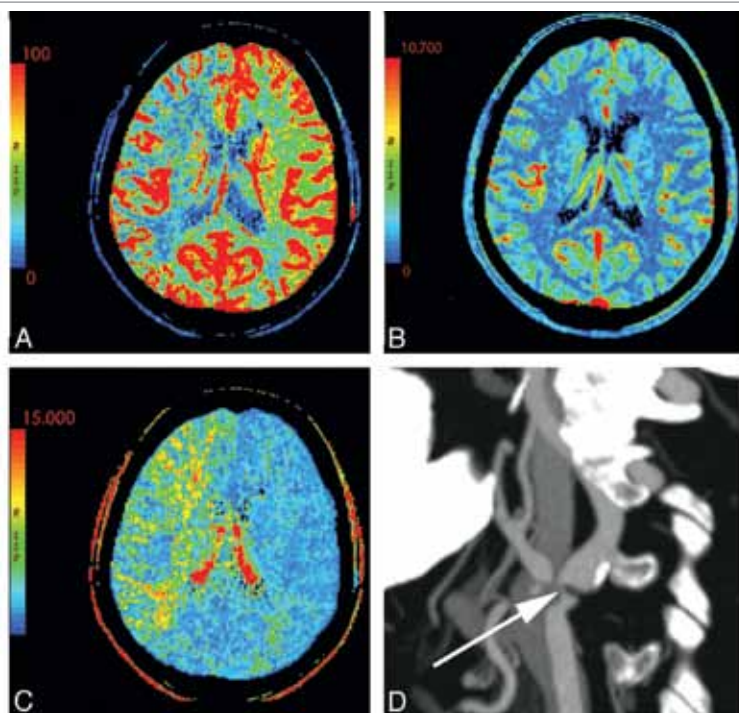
A 76-year-old man with change in mental status. NCCT findings (not shown) were normal. A–C, There is decreased CBF (A) and prolonged MTT (C) in the right MCA and ACA territories with preserved CBV (B). D, CTA reveals severe right ICA stenosis at its origin (arrow).
